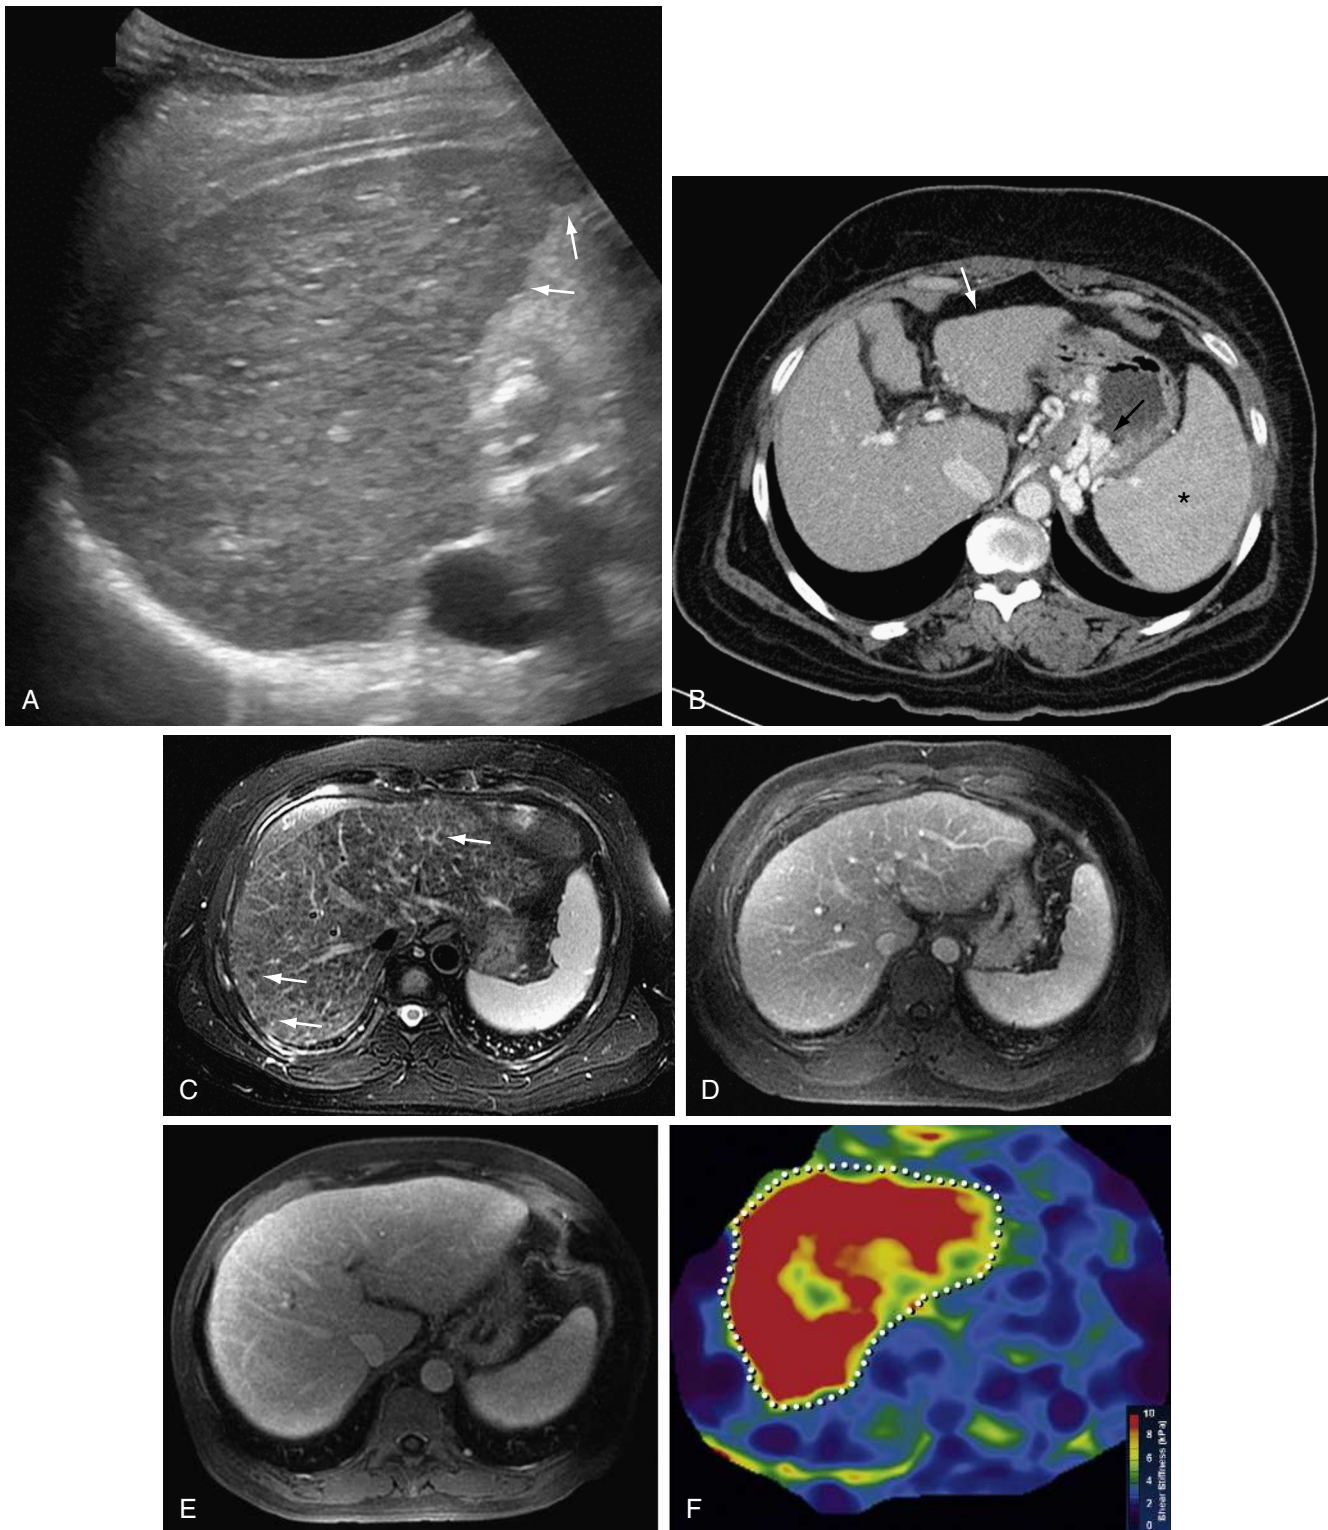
Imaging in cirrhosis. *A*, A transverse US image of the right lobe of liver demonstrates the characteristic heterogeneous liver parenchyma with surface nodularity (*arrows*). *B*, Axial contrast-enhanced CT image shows a nodular left lobe of the liver (*white arrow*). Note the gastric and esophageal varices (*black arrow*) and splenomegaly (*asterisk*). *C*, Images from T2-weighted and *D*, contrast-enhanced T1-weighted MRIs show hypointense siderotic nodules (*white arrows*) and an enlarged left lobe and splenomegaly. *E*, Contrast-enhanced MRI shows a heterogeneous liver with an enlarged left lobe. *F*, A stiffness map from magnetic resonance elastography shows increased stiffness of the liver (*dotted outline*), with a mean stiffness value of 9.2 kPa. The normal liver stiffness value is less than 2.93 kPa. (*F*, From Yin M, Talwalkar JA, Glaser KJ, et al. Assessment of hepatic fibrosis with magnetic resonance elastography. Clin Gastroenterol Hepatol 2007; 5:1207-13. Other images courtesy Sudhakar Venkatesh, MD, Rochester, Minn.)
